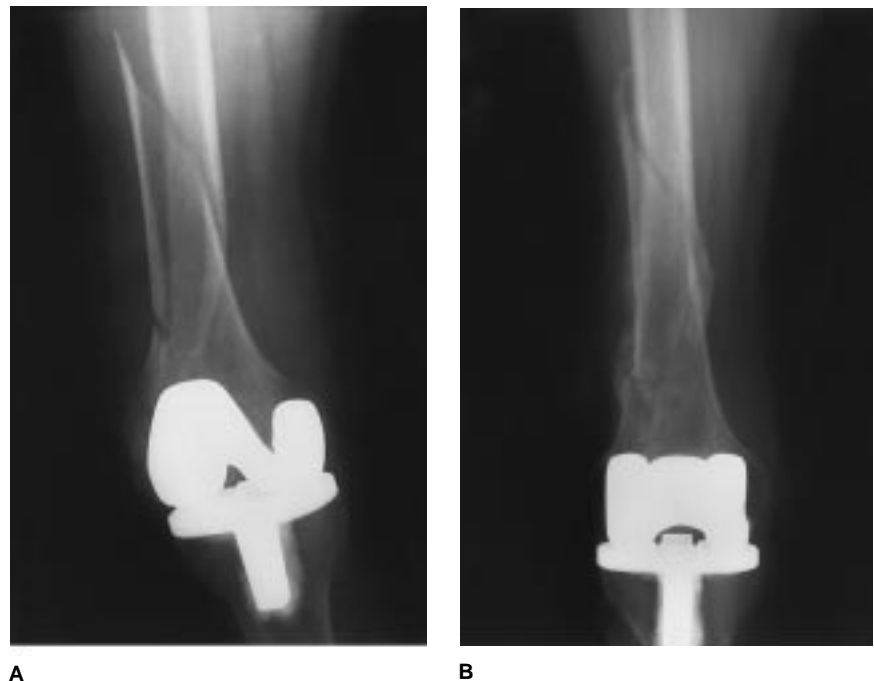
A, Anteroposterior radiograph of the knee of a 63-year-old woman with corticosteroid-dependent rheumatoid arthritis who sustained a supracondylar femoral fracture 7 years after total knee replacement. B, The fracture was reduced by closed means and treated in a cast brace. Patient's ambulatory status and range of motion were maintained at their prefracture level.
